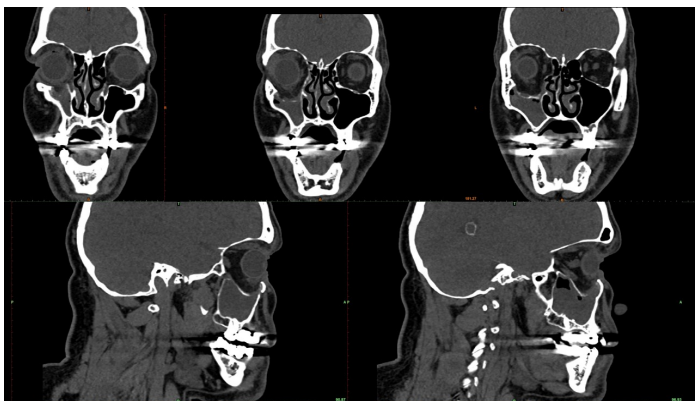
CT examination of the patient: fracture of the lower wall of the right orbit, as well as displacement of the right zygomatic bone, accompanied by protrusion of the periorbital tissue and the defective side of the lower rectus muscle
